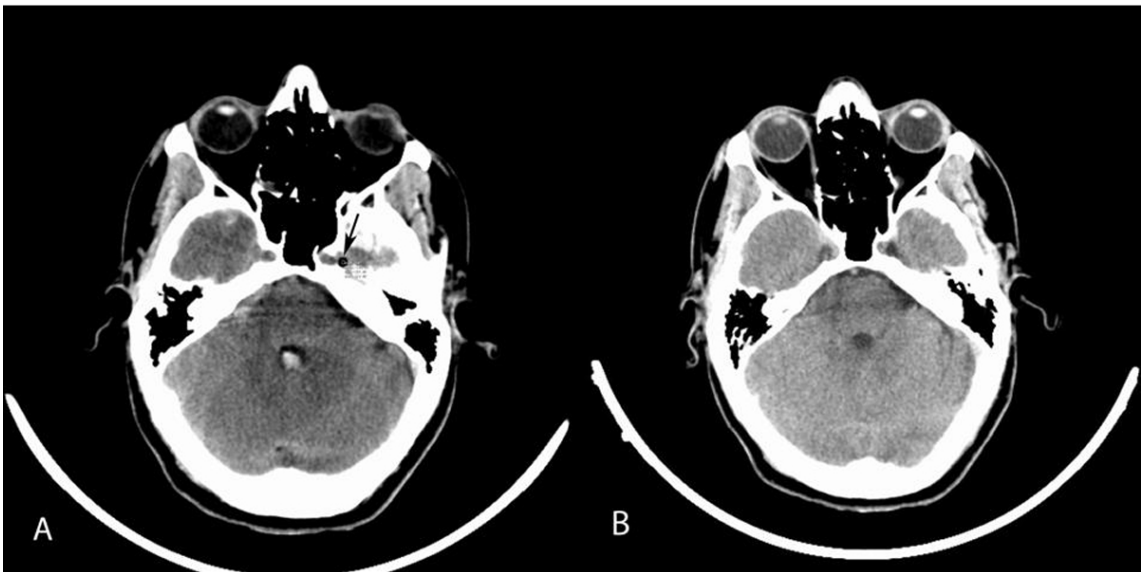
CT scan one hour after the procedure (A) showing an air bubble in the left cavernous sinus (black arrow), and after 3 days on control CT (B) it is gradually absorbed and disappeared.
